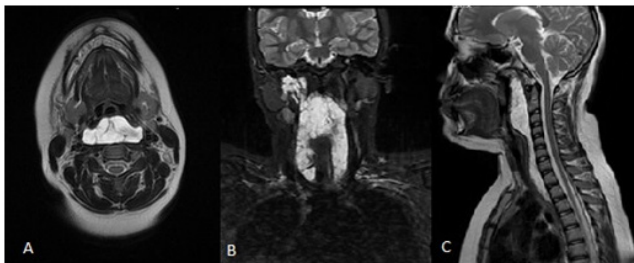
Preoperative T2W1 MRI of retropharyngeal mass; the lesion was presented as hyperintense from the surrounding tissue. A: Axial section, B: Coronal section, C: Sagittal section.
